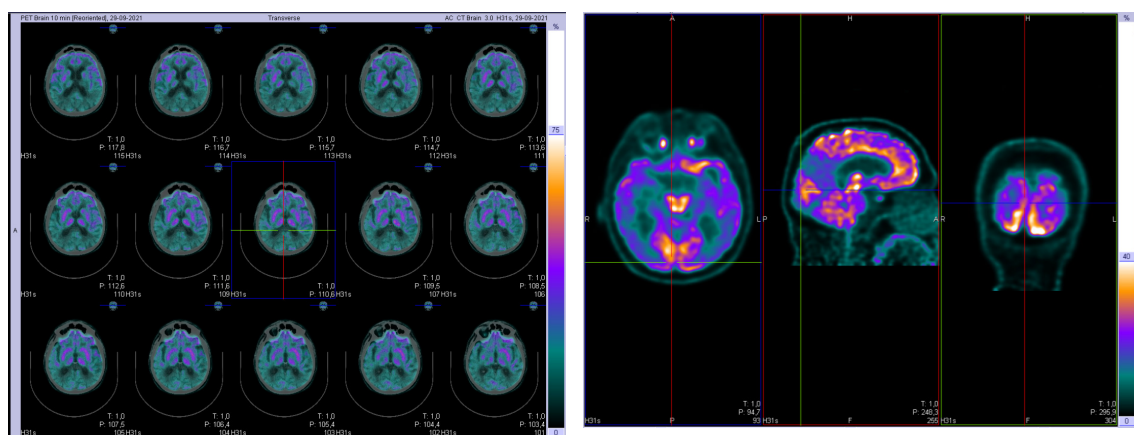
Brain PET with 2-[¹⁸F]-FDG showing bilateral temporoparietal hypometabolism, most evident in the precuneus and posterior cingulate, suggestive of Alzheimer's dementia.
